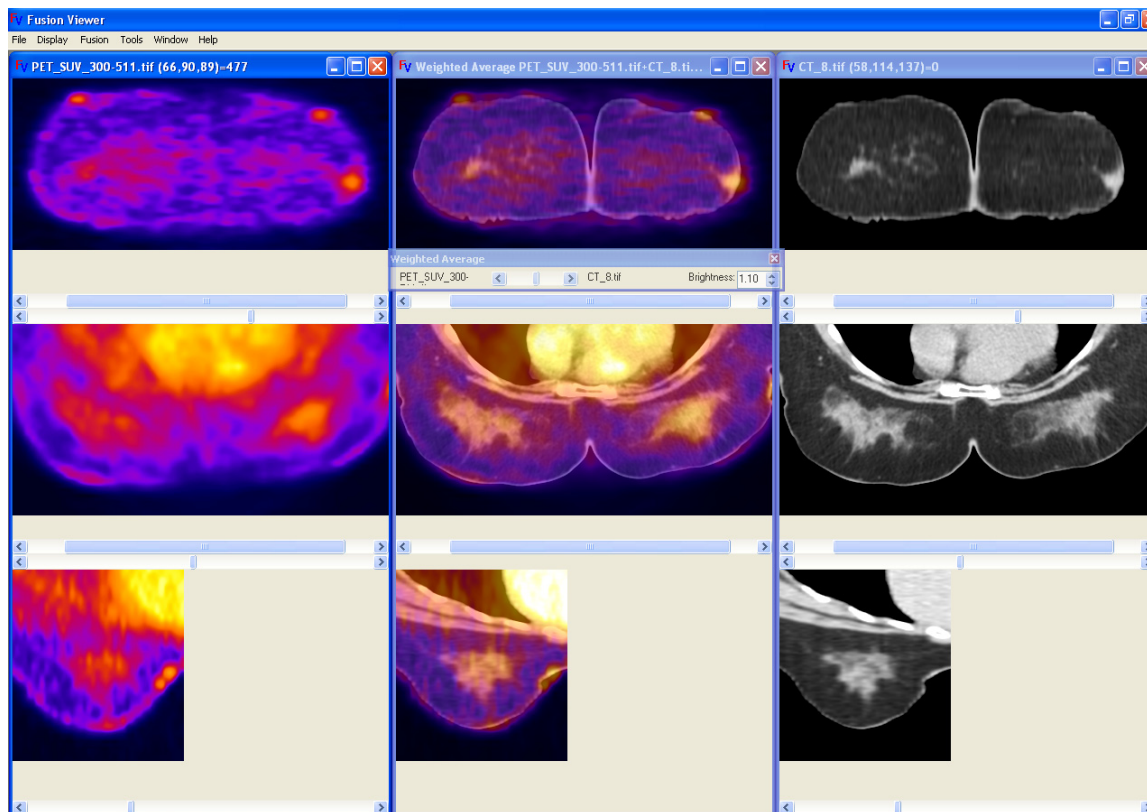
A screenshot of a fused data set created using the Fusion Viewer software. The three orthogonal images on the left are from the PET data set after the application of the Fire color table, the three orthogonal images on the right are from the CT data set. The three orthogonal images in the center are from fusing the PET and CT images using the weighted average fusion plug-in. In essence the coloring of the CT image is based on the PET intensity values. Not only can we see the anatomical structure, but we can also see the metabolic activity for each structure.
